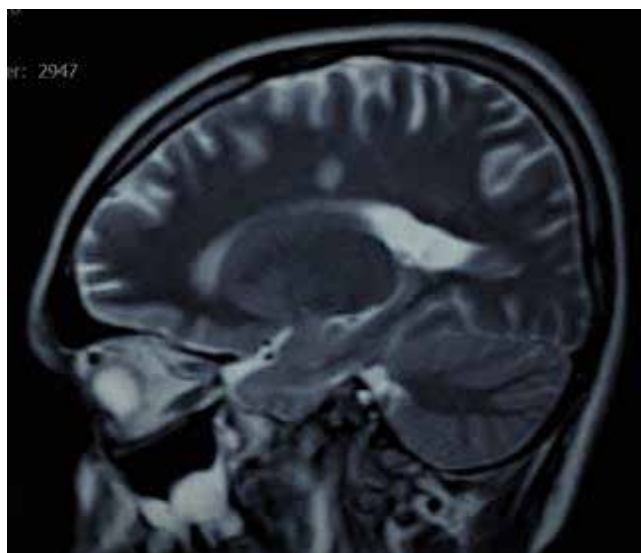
MRI T2 sagittal section ischemic/demyelinating lesion perpendicular to the corpus callosum
